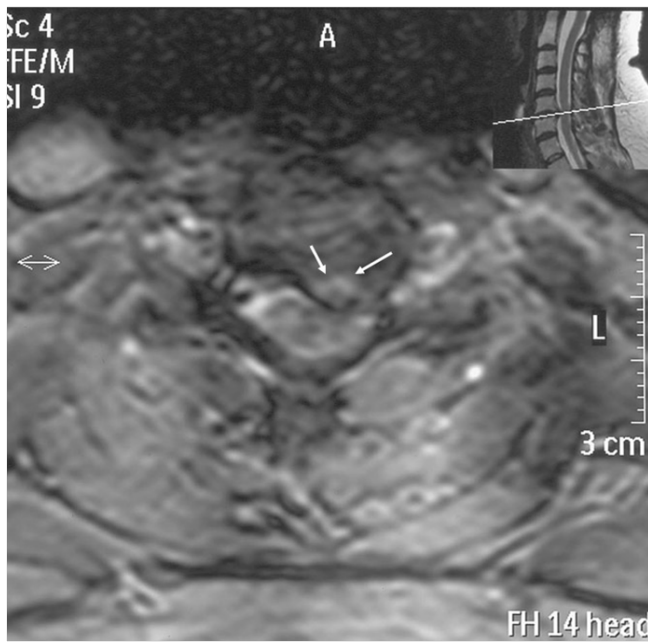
Transverse T2-weighted MRI section through the C5-C6 area revealed the herniated disk fragment to compress the left anterolateral spinal cord. MRI: magnetic resonance imaging
